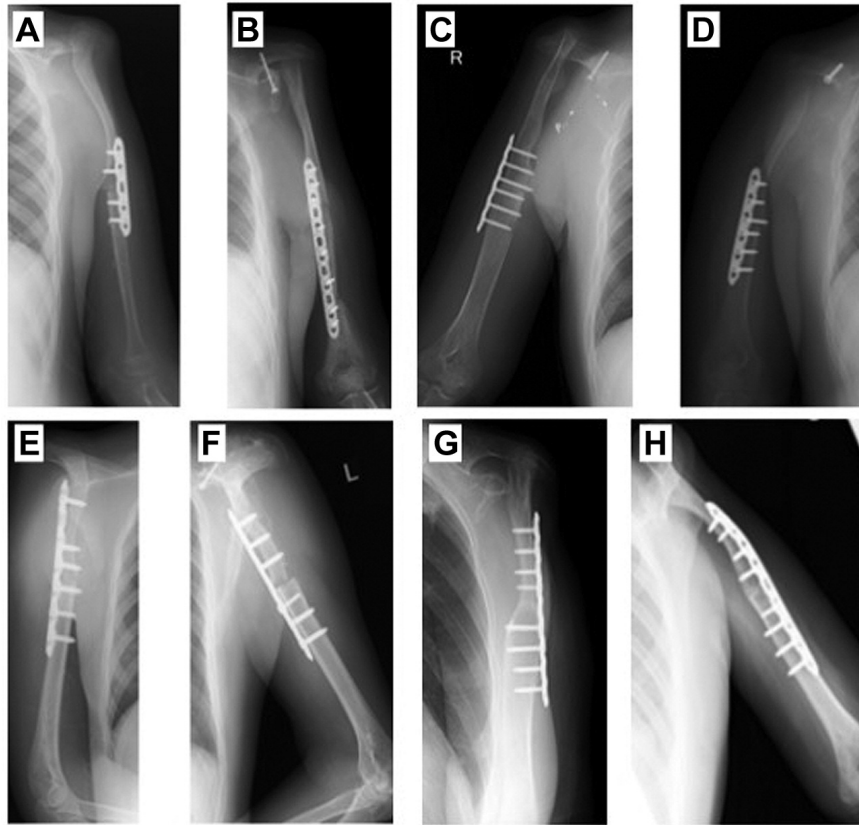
Postoperative x-ray of patients 1-8, respectively. A: The total humerus was removed and reconstructed with only the clavicle being rotated and with vascularized fibular autografts. The elbow joint was reconstructed with a fibular head. B: Clavicle pro humero reconstruction was performed with a rotated clavicle, vascularized fibular autograft and residual humerus. C-H: Reconstruction was performed with only a rotated clavicle and residual humerus.
